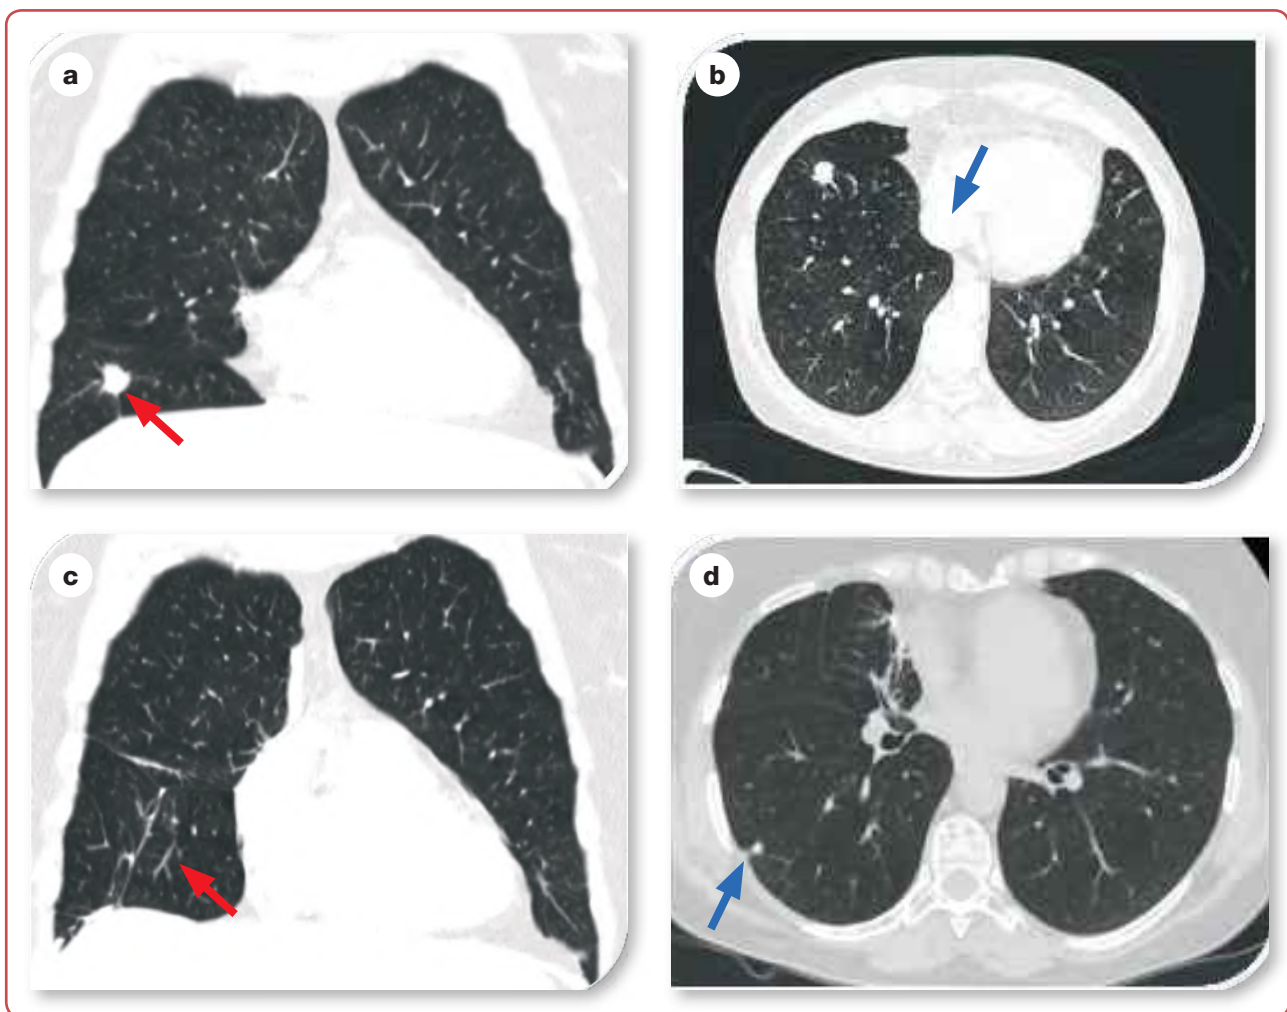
Contrast-enhanced CT image of the chest showing: a) tumour in the right lung's lower lobe with spiculated margins, measuring 14x12x16 mm (red arrow) that retracts the pleura; b) solid lesion in the right middle lobe, in close proximity to the pericardium with adjacent adhesions (blue arrow); c) fibrotic alterations in the right lower lobe after surgery (red arrow); d) subpleural nodule measuring less than one cm in segment S6 of the right lung after surgery (blue arrow).
